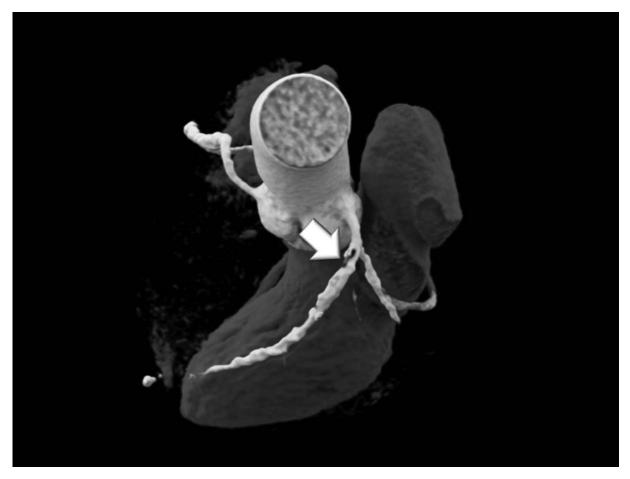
Sixty-year-old man with four risk factors [arterial hypertension, smoking, positive family history, dyslipidemia (cholesterol 204, low-density lipoprotein 125 mg/dl) and chest pain]. CTA showed a more than 70% stenosis and high-plaque load (G-score 20, SIS score 12), and proximal low attenuation fibrofatty plaque (52 HU). Thirty-one years of HIV infection and 21.5 years on ART. CTA showed and ectatic RCA with a more than 50% stenosis (left panel) and an ectatic LAD with a more than 70% stenosis in the proximal LAD (right panel, white arrow). High-risk plaque in the proximal LAD with low-attenuation fibrofatty plaque (52 HU) (white arrow). CTA, computed tomography—angiography.
